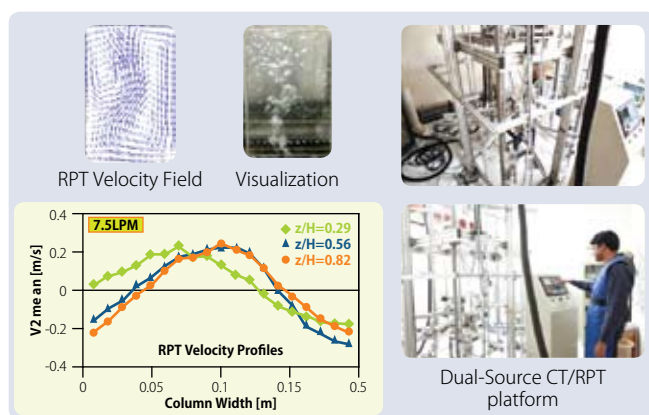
Hydrodynamic investigations using Radioactive Particle Tracking (RPT) and Gamma-Ray Tomography (CT)
